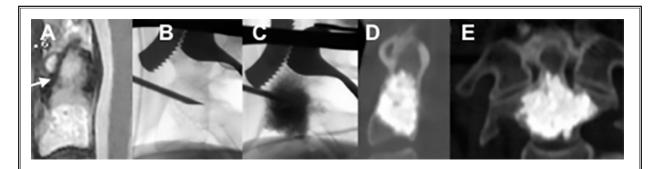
C2 symptomatic vertebral hemangioma. (A) T2 weighted MRI demonstrates a C2 hemangioma, (B) 13 gauge needle inserted into vertebral body through transoral approach, (C) cement injected, (D, E) post-procedural CT images demonstrates lesion being filled with cement.
